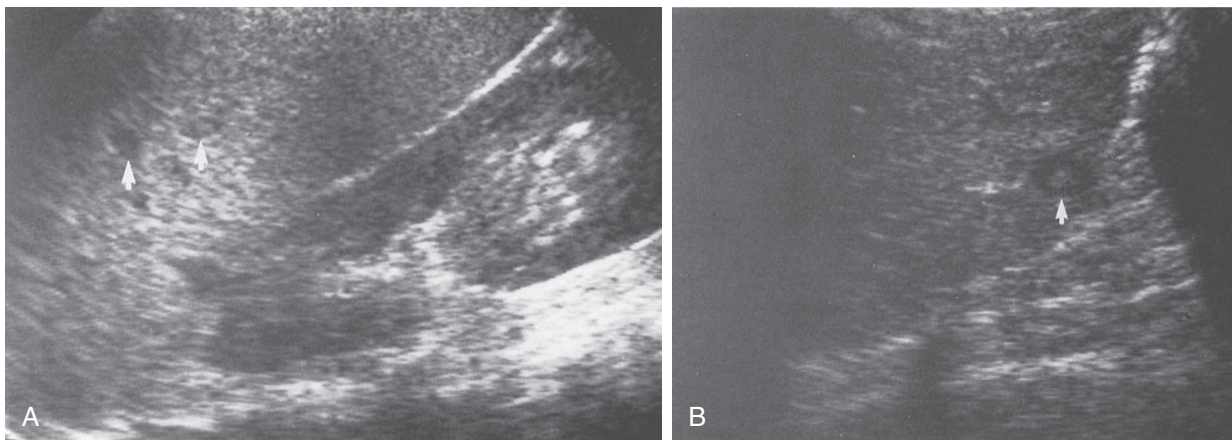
A 10-year-old girl had been treated for acute myelogenous leukemia. She had taken multiple antibiotics for recurrent infections. Unrelenting fevers then developed. Candidiasis was strongly suspected, and ultrasonography was requested. Two weeks after the clinical suspicion of candidiasis was raised, obvious focal defects (arrows) could be seen within the spleen (A) and liver (B).
